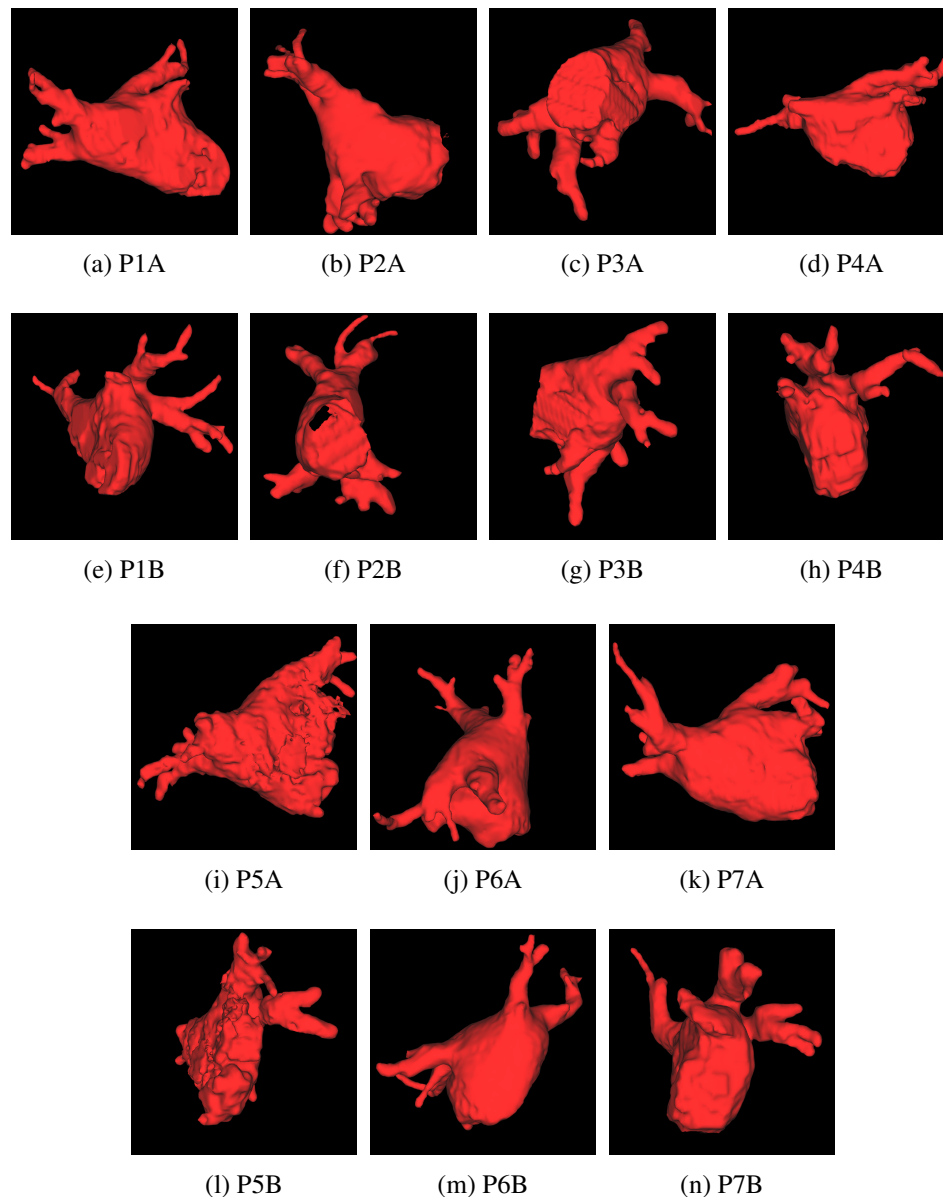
The 7 meshes after segmentation from MR images.
